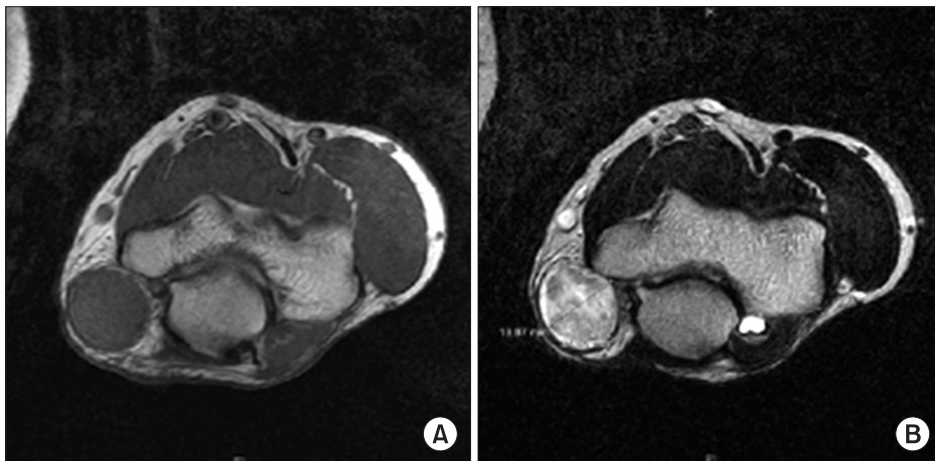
(A) Axial T1-weighted image showed ovoid mass with low signal intensity which is isointense to surrounding muscle. (B) Axial T2-weighted image showed ovoid mass with high signal intensity. Compose of hypointensity on marginal area and hyperintensity on central area.
